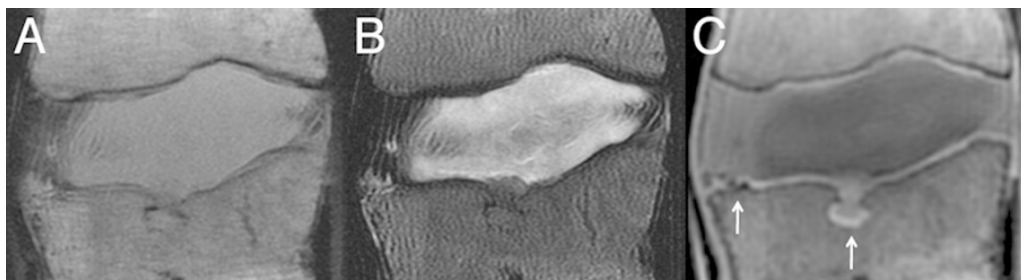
Comparison of 3 different imaging techniques to assess the optimum settings to visualise the VEP with the MRI. A: Midsagittal T1-weighted MRI of L1-L2 motion segment with poor end plate signal. B: T2-weighted MRI of L1-L2 motion segment with poor end plate signal. C: Corresponding ultrashort time-to-echo (UTE) MRI image showing enhanced end plate signal. Arrows indicate end plate defects [3].
